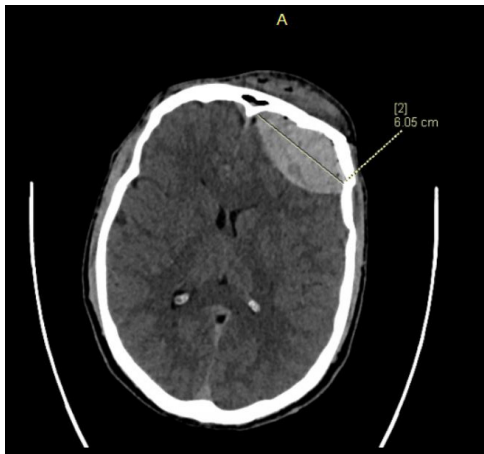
Computed tomography of the patient from case 1 – epidural hematoma (32 x 60 x 60 mm) with isolated air bubbles in the left frontal region is visible
